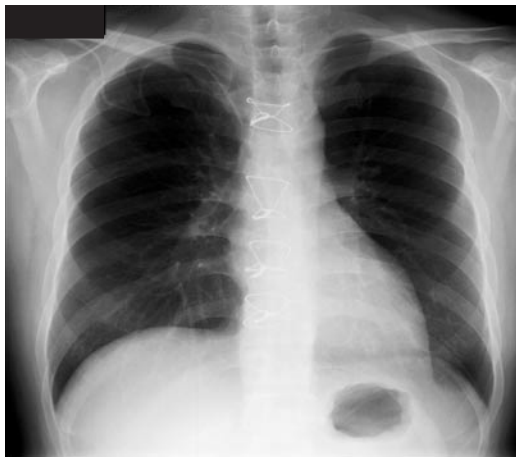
Chest X-ray on emergent arrival is uneventful regarding his heart.
